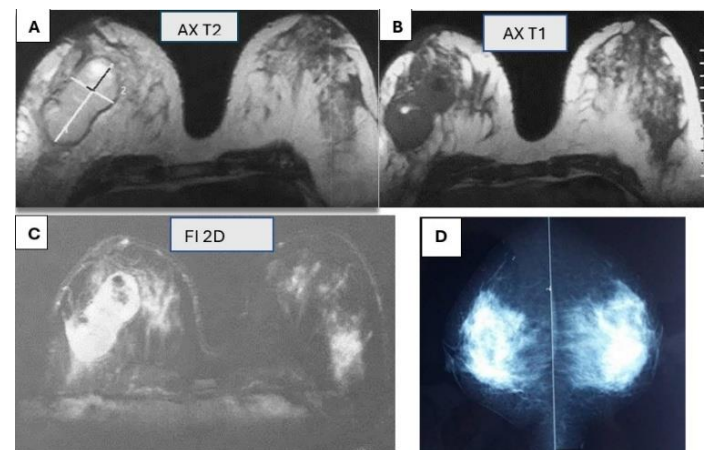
A, B, C: Breast magnetic resonance imaging showing a bilobed mass enhancement of the external quadrants of the right breast. D: Standard mammogram showing asymmetric density of the right breast corresponding to the mass already shown on A B C
